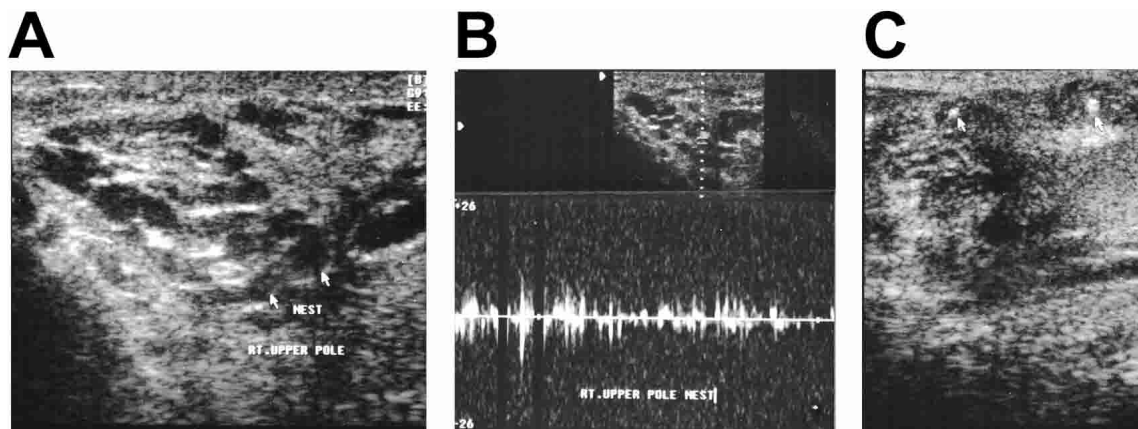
Pretreatment ultrasound appearance (A) and pulsed Doppler tracing (B) from a man with lymphatic vessel dilation and several filarial nests identified at the upper pole of the right testis. This subject experienced scrotal discomfort one week after treatment. C, Intrascrotal calcifications and decreased lymphatic vessel dilation in this area 12 months after treatment with diethylcarbamazine/albendazole.
